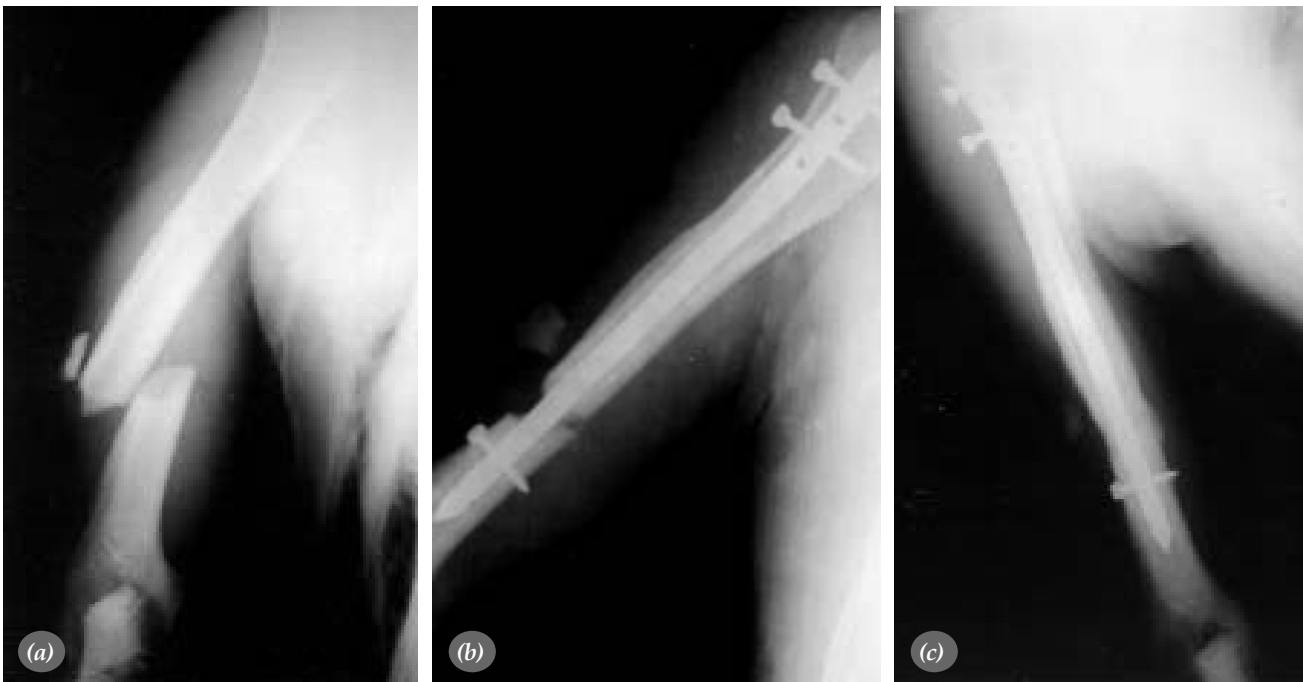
(a) Preoperative AP radiography view of midshaft fracture in a 52 years-old male. (b) Radiography view after treatment by intramedüller nailing. (c) Radiography view after two years.
